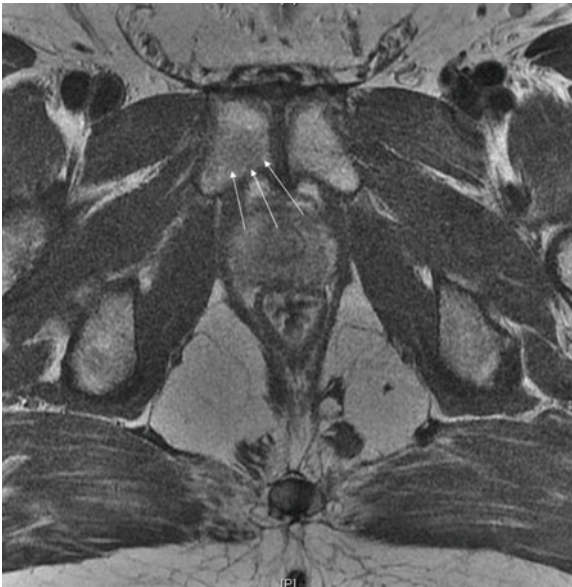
Osteitis pubalgia on MRI.
